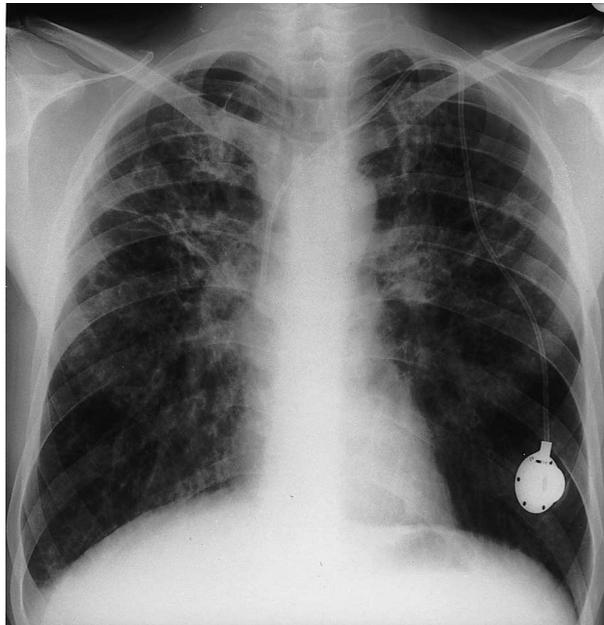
Chest X-ray of this 37-year-old man with cystic fibrosis shows hyperinflation, peribronchial thickening, cystic bronchiectasis and perihilar fibrosis. A Portacath central venous system is in place with the access port situated subcutaneously in the left lower chest. He has chronic *Pseudomonas aeruginosa* infection and receives about three courses of intravenous
